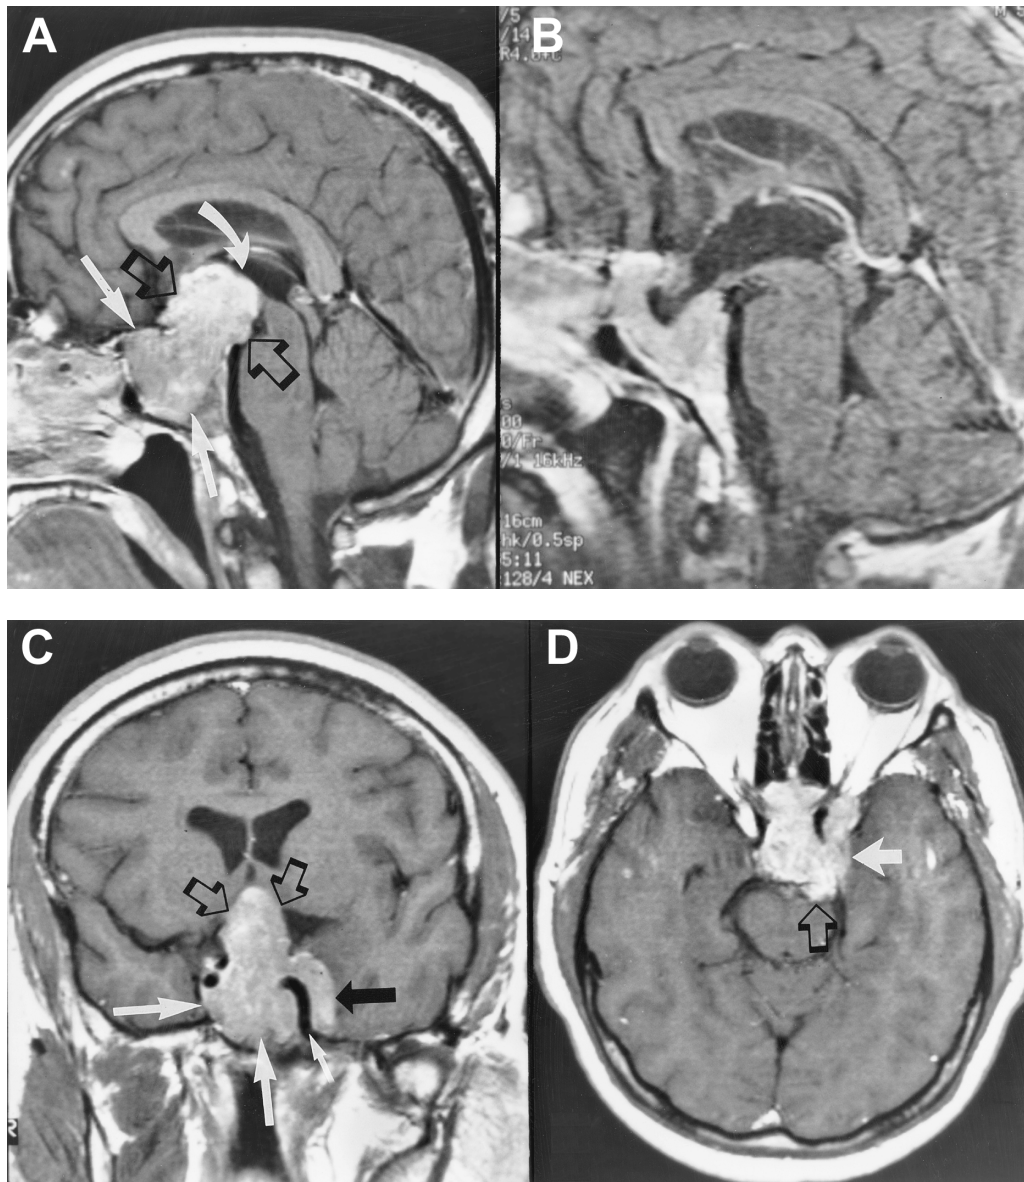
Pituitary adenoma (prolactinoma). Post-contrast sagittal MRI scans, pre-bromocriptine (A) and post-bromocriptine (B) therapy. There is a very large intrasellar mass (arrows) with a suprasellar extension (open arrows) compressing the optic chiasma and anterior third ventricle (curved arrow) as shown in A. A dramatic decrease in suprasellar and intrasellar tumor followed bromocriptine therapy (B). Post-contrast coronal MRI of the pituitary (before therapy; C) reveals the intrasellar mass (large white arrows) and the suprasellar extension (open arrows). The tumor extension to the cavernous sinus (black arrow) and the relationship of the tumor to the internal carotid artery (small arrow) are best demonstrated in this projection. Post-contrast axial MRI of the brain (before therapy; D) shows the parasellar (arrow) and posterior fossa (open arrow) extension of the tumor.
